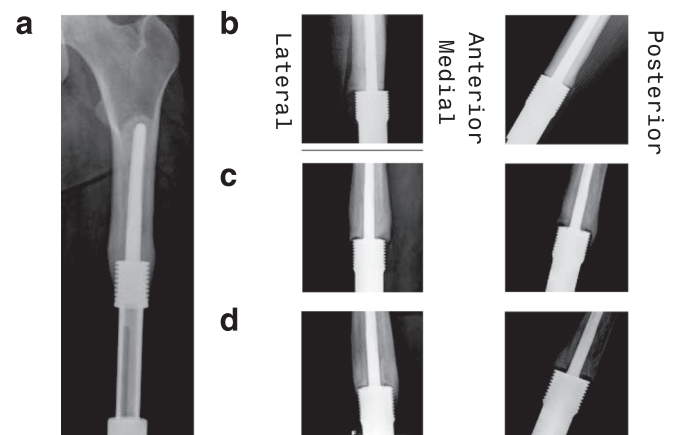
(a) M-L radiograph of patient taken 12 years after prostheses implanted at age of 7 years; M-L views [left] and A-P views [right] of set of X-rays from implanted femur for different patient taken: (b) immediately post surgery; (c) one year post surgery; (d) two years post surgery.
